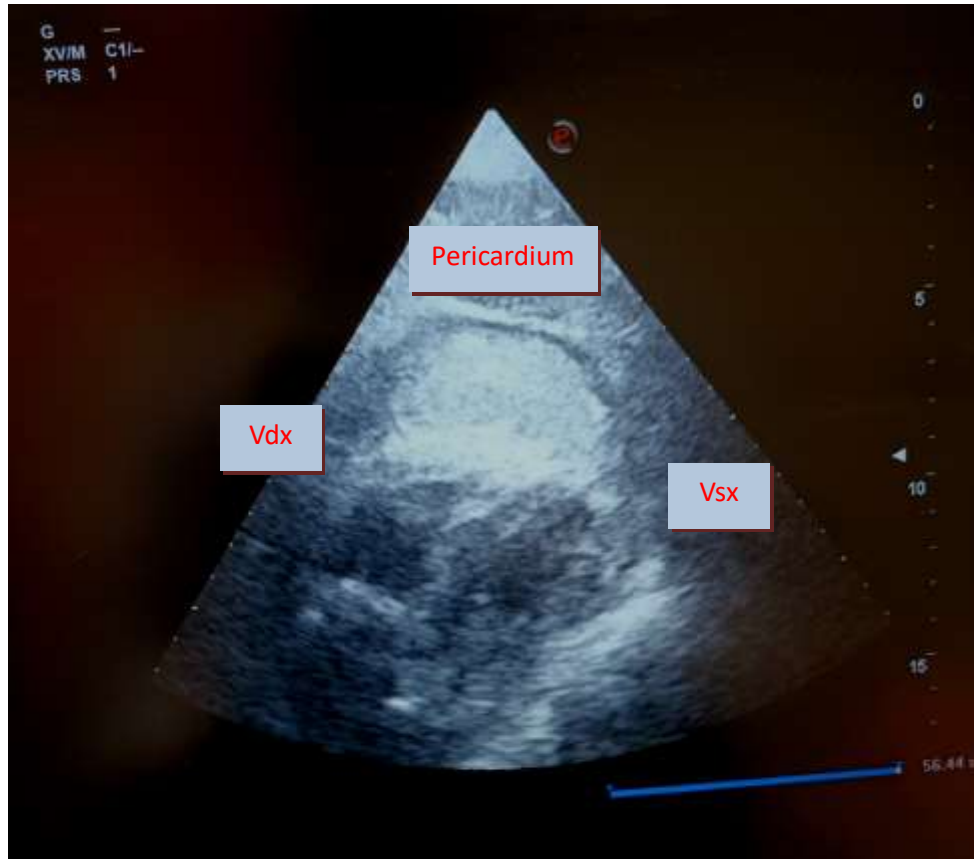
Heart Rupture: Transthoracic echocardiogram by subcostal window.
